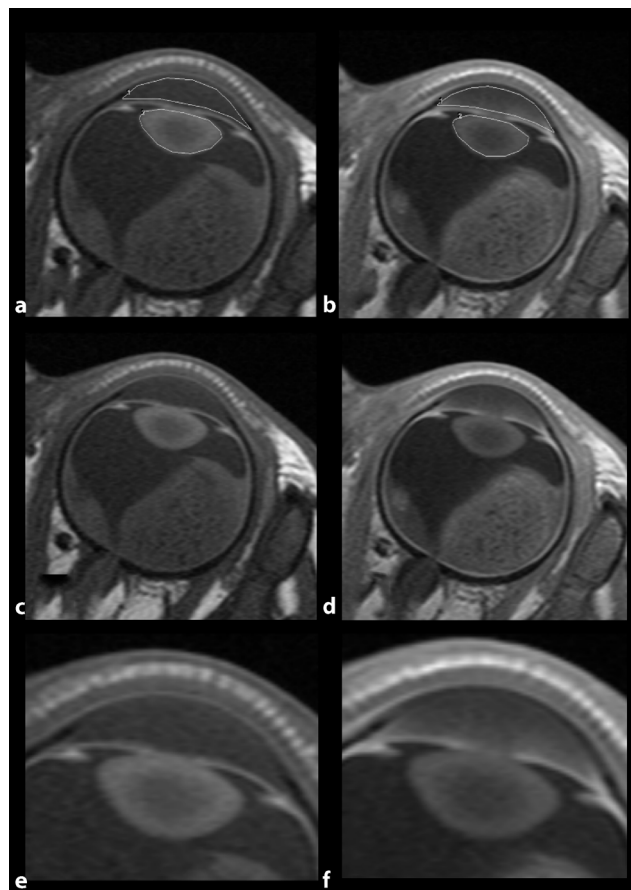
183 Example of orbital MRI and applied image analysis
